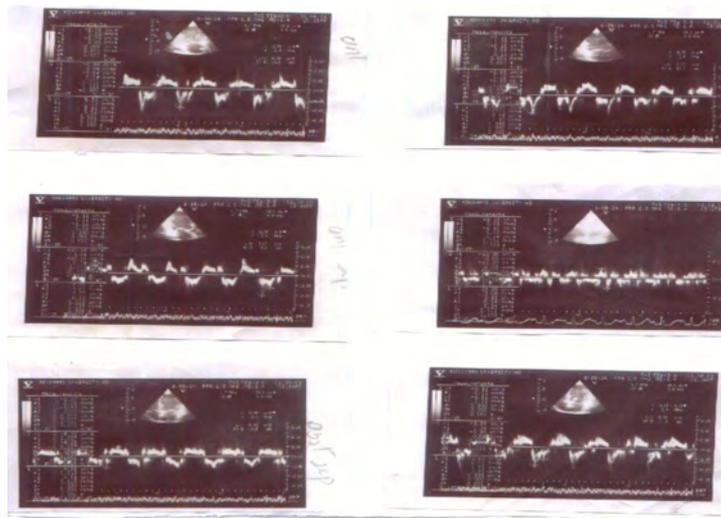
Tissue Doppler parameters on patient No (1)
